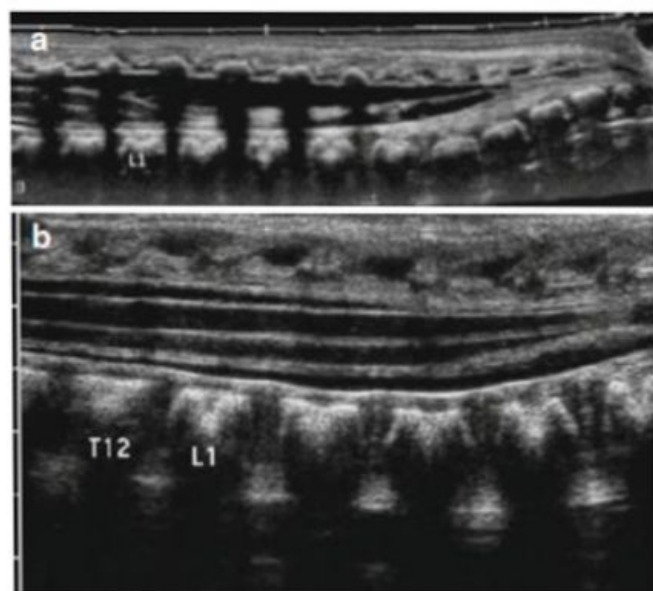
Spinal Ultrasound. (a) Normal location of the conus. (b) Tethered cord
